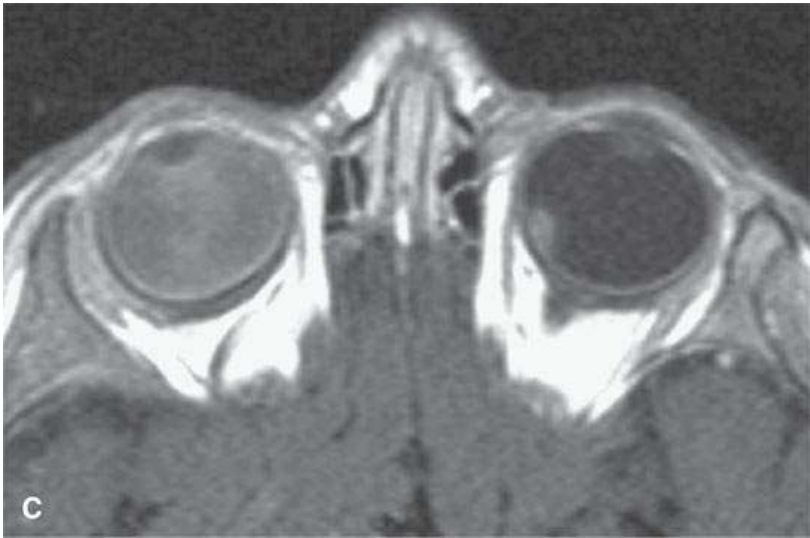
Useful, potentially misleading, and useless and potentially misleading patterns of calcification. The first two cases are useful. A: Contrast-enhanced computed tomography (CECT) of a child with leukocoria of uncertain etiology with an unmistakable calcified retinoblastoma confined to the globe as a cause of the leukocoria and complete retinal detachment. B, C: Another child with retinoblastoma bilaterally with the diagnosis much more obvious on the CECT in (B) than the T1-weighted contrast-enhanced magnetic resonance in (C). The following case is potentially misleading. D: CECT shows a nasal cavity olfactory neuroblastoma with extensive (atypical) calcification that might lead some down the wrong diagnostic pathway based on imaging, although biopsy is the prime determinant. The following case is useless and potentially misleading. E: Leiomyosarcoma of the prestyloid parapharyngeal space with a cystic change and calcification (likely dystrophic) that would likely lead to a main consideration of a benign salivary gland neoplasm. The calcification cannot be used to add specificity to the diagnostic process.
